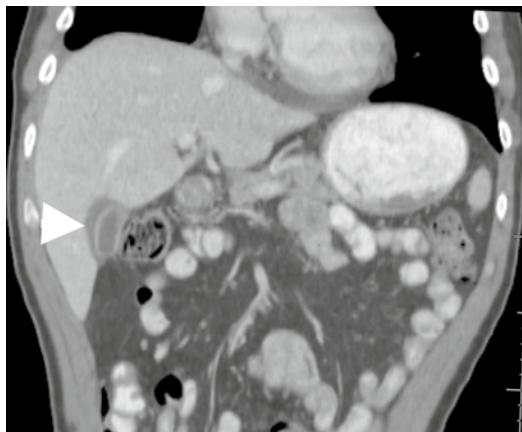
Pericholecystic fluid due to everolimus. A 45-year-old male with advanced metastatic renal cell carcinoma treated with daily everolimus $\times 6$ weeks. Restaging coronal CT shows interval development of pericholecystic fluid (arrowhead). The development of pericholecystic fluid and ascites can occur as a result of chemotherapy and is not necessarily diagnostic of inflammation or progression of disease
